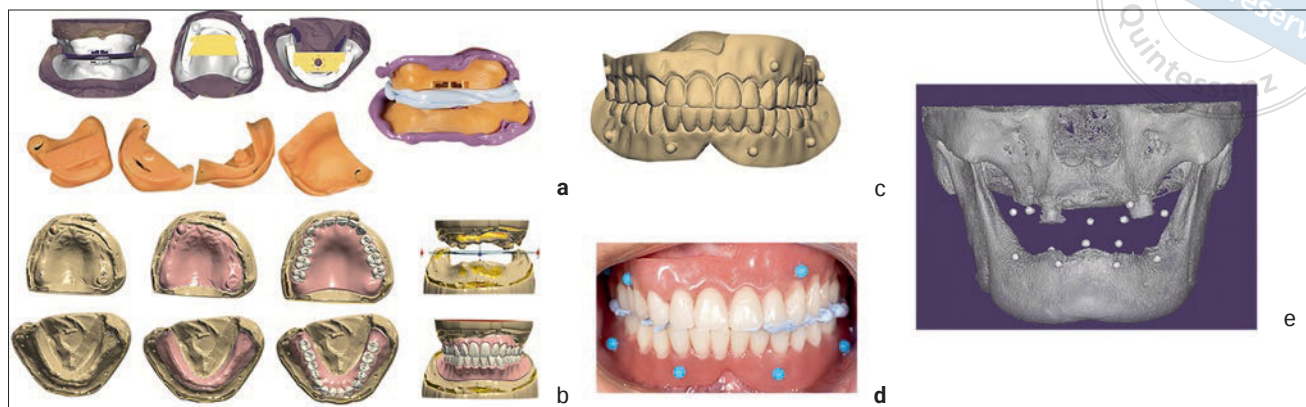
to d Radiographic guide (interim conventional complete dentures). Fabrication of the custom trays with Gothic arch to record centric relation (a); process of designing the radiographic guide using digital design software (b); centric relationship and anterior aesthetics recording with radiographic guide and interocclusal record in place (c); STL file of radiographic guide (d); preoperative CBCT data (e). STL, standard tessellation language.
